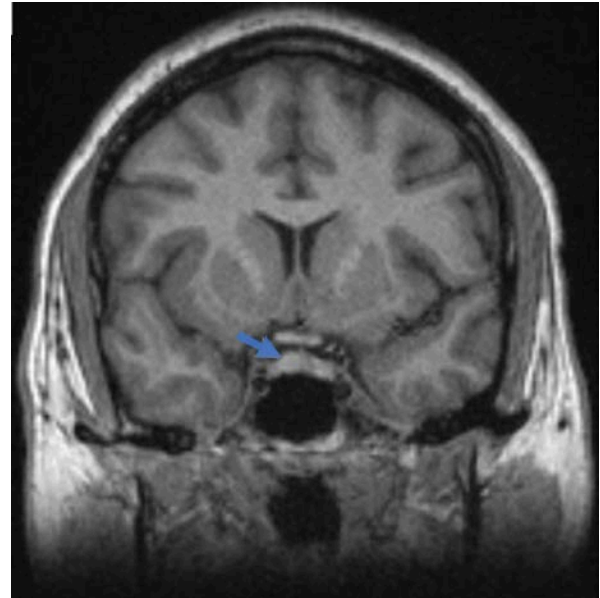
Brain MRI brain without contrast, coronal.
